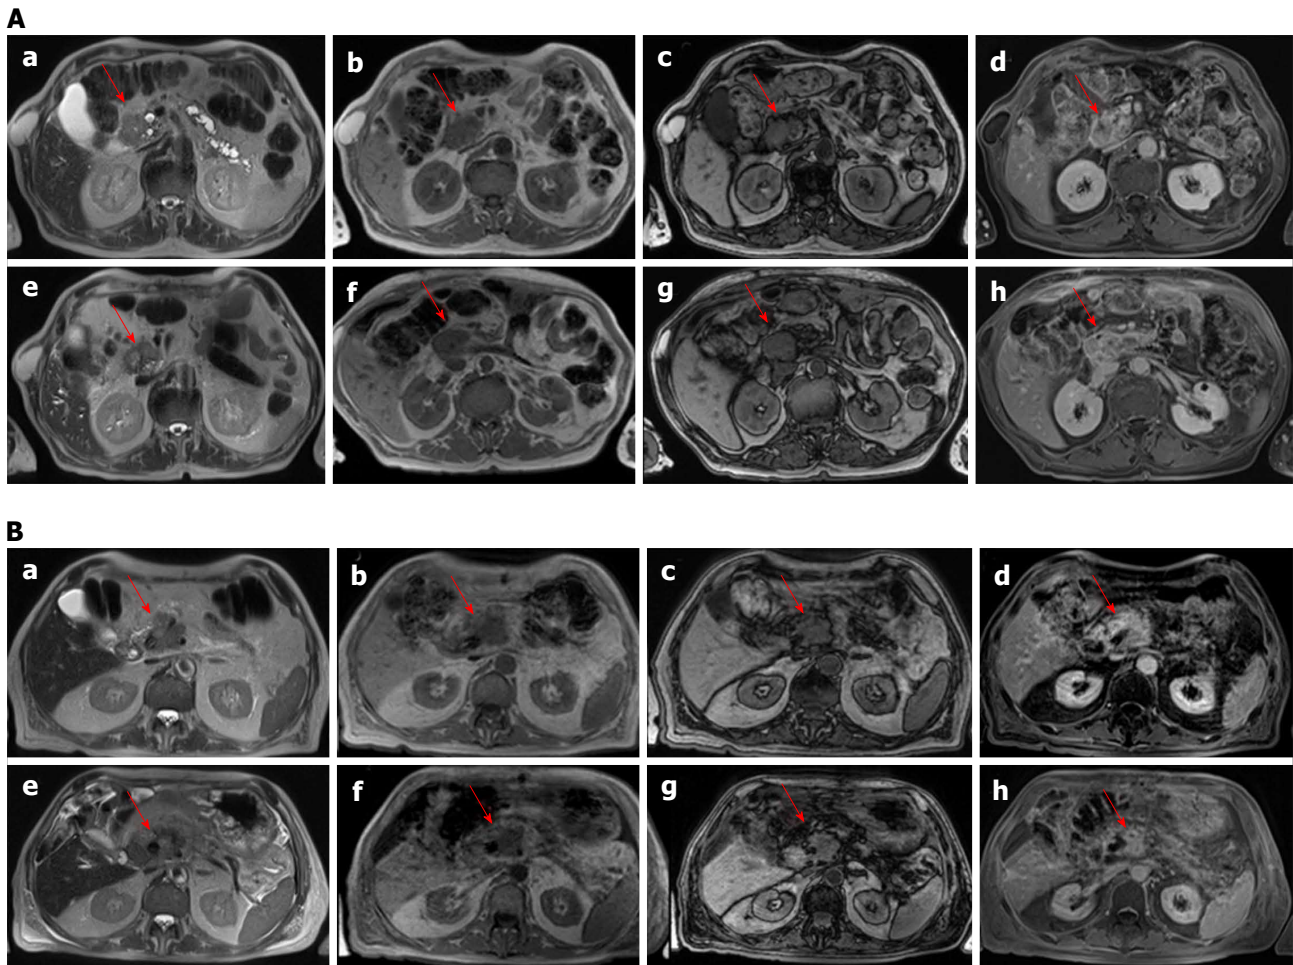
Magnetic resonance imaging assessment using morphological criteria for two patients (in A man 79 years old and in B man 74 years old). Before treatment in HASTE T2-W sequence (a), the lesion (arrow) appears hyperintense, in in-phase T1-W sequence (b) and out-phase T1-W sequence (c) appears hypointense and hypovascular in VIBE T1-W in equilibrium phase (d). After the treatment the lesion in HASTE T2-W sequence (e), in-phase T1-W sequence (f), out-phase T1-W sequence (g) and VIBE T1-W in equilibrium phase (h): there were not significant differences in signal compared to the similar before the treatment. HASTE: Half-Fourier Acquisition Single-Shot Turbo Spin-Echo; VIBE: Volumetric Interpolated Breath-hold Examination.
